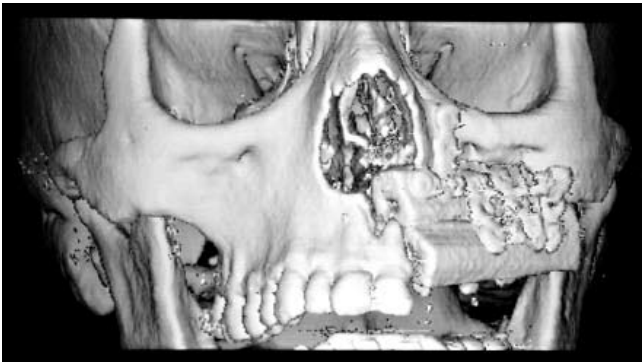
Computed tomography showing 3D reconstruction of native maxilla with fibula free-flap.
